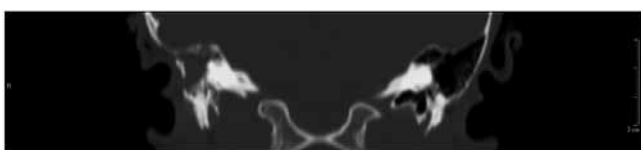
Pre-anti-TB treatment temporal bone CT scan of case report 2.
